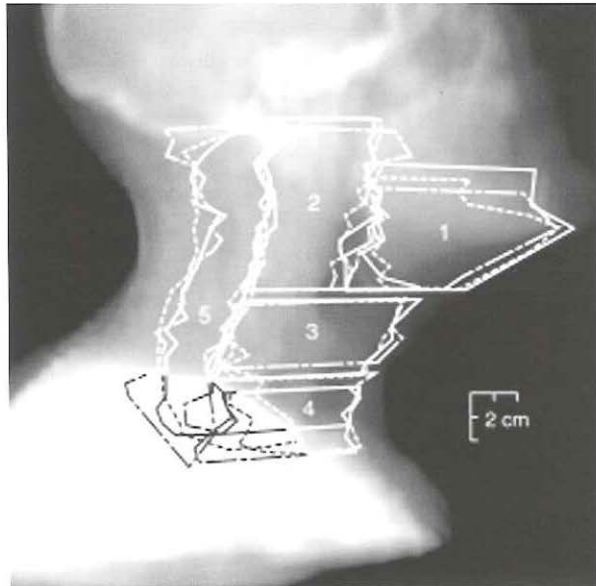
Delineation of the elective target in the neck by three radiation oncologists. Regions 1 through 5 were delineated on CT scans. A beams-eye-view reconstruction of these regions was superimposed on a digital reconstructed radiograph. Only minor deviations are seen in the beams-eye-view images. The targets are in good agreement with clinical practice.
